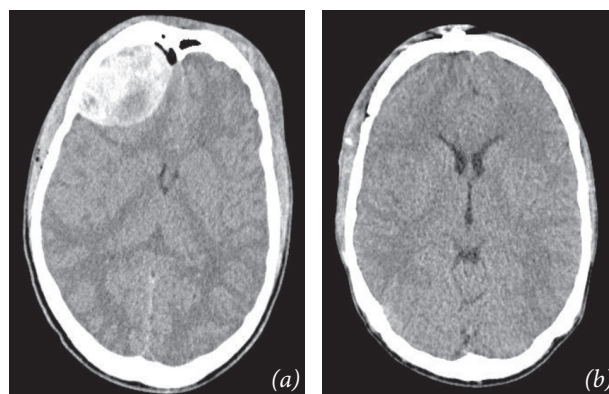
(a) Right frontotemporal epidural hematoma in a non-enhanced CT scan in a 32-year-old female after a fall during an epileptic seizure. GCS 8, anisocoria with absent pupillary reactivity; (b) the same patient, post-operative trepanation and hematoma evacuation.
